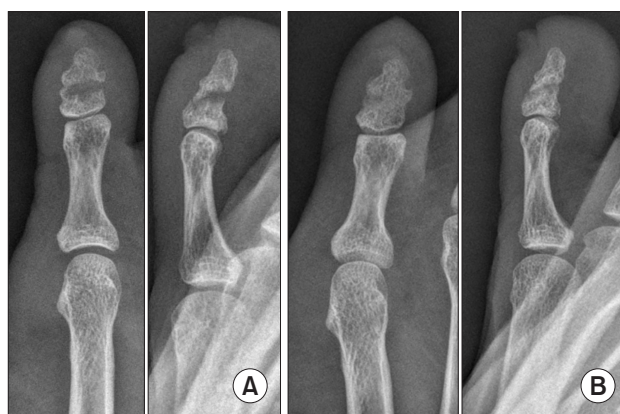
(A) A representative radiograph of the fifth symphalangeal fracture at the initial state. (B) Achievement of the complete union at the final follow-up (5 months from initial injury).
